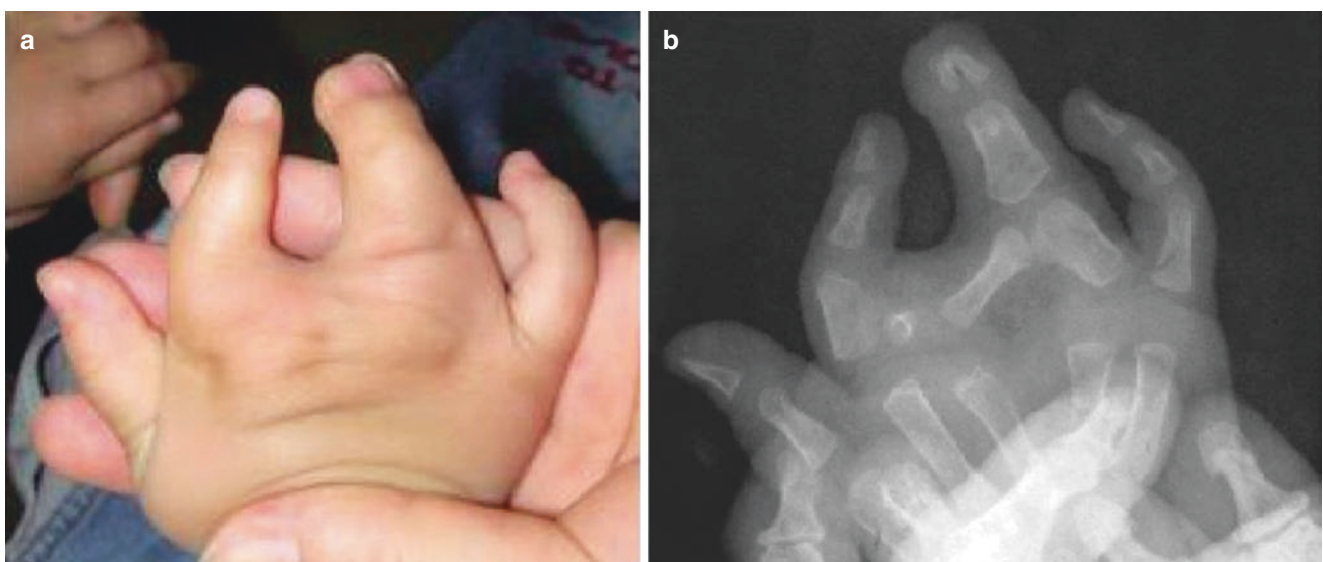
Combined syndactyly: the phalange or the finger is inserted between the abnormal fingerwebs. (a) Hand appearance. (b) X-ray findings
